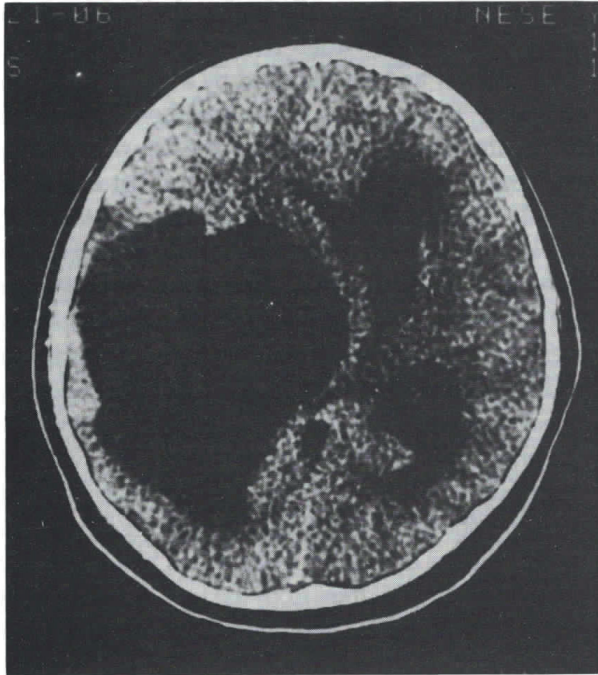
(Case 1) Plain CT scan shows a large temporoparietal cyst.
